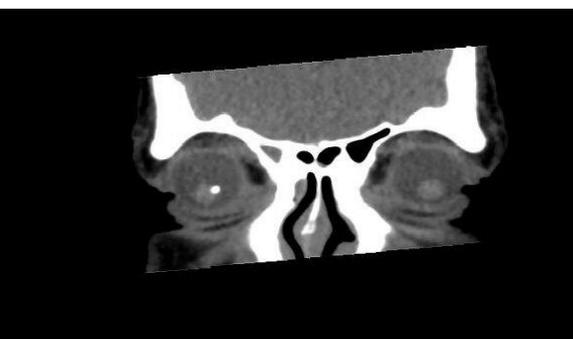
IOFB- coronal CT-scan orbits reveals Rt intraoculr metal FB
